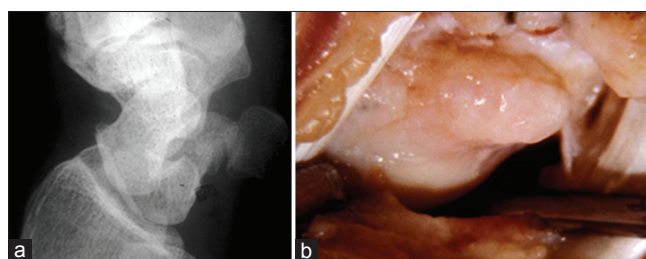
In dorsal wrist syndrome, the inflamed synovium produces peripheral osteophytes as noted on the dorsum of the scaphoid in this oblique X-ray (a) and at surgery (b)
